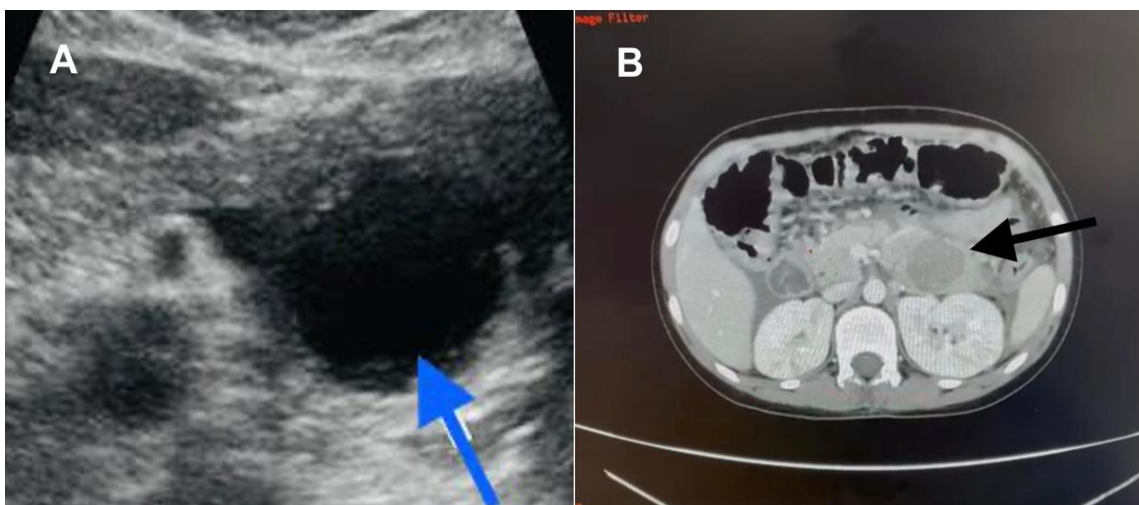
Ultrasound revealed a large unilocular non-septated distended cystic swelling seen in the midline anterior to the spine and extending to the left side, with few internal echoes (blue arrow)
